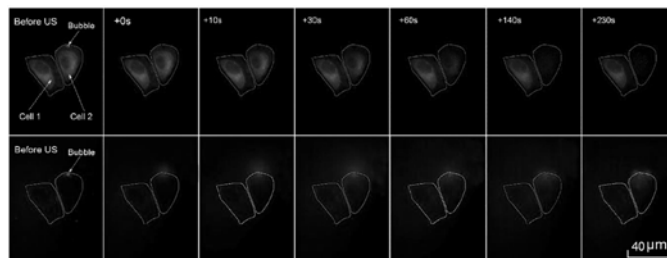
Cell membrane and cytoskeleton response under ultrasound irradiation. From Fan et al [104]. Copyright ©2017 Theranostics, reproduced with permission.
